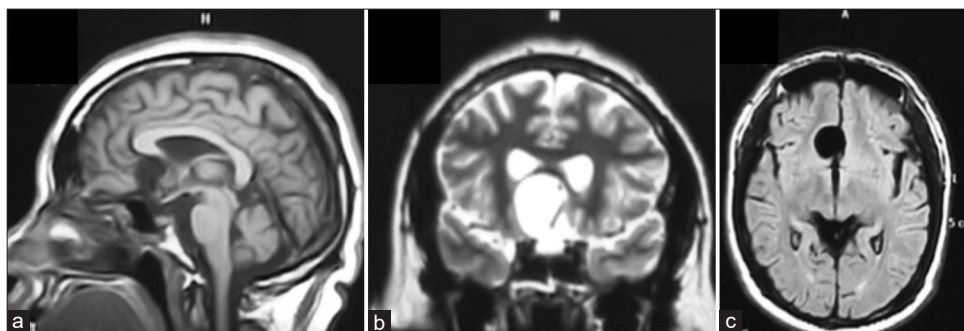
Magnetic resonance imaging study of case 1. (a) T1-weighted sagittal plane, hypointense lesion in the sellar region with extension to the suprasellar area adjacent to the mesial frontal area. (b) T2-weighted coronal plane shows the consistency of cystic lesion, (c) with minimal perilesional edema in axial fluid attenuated inversion recovery image.
